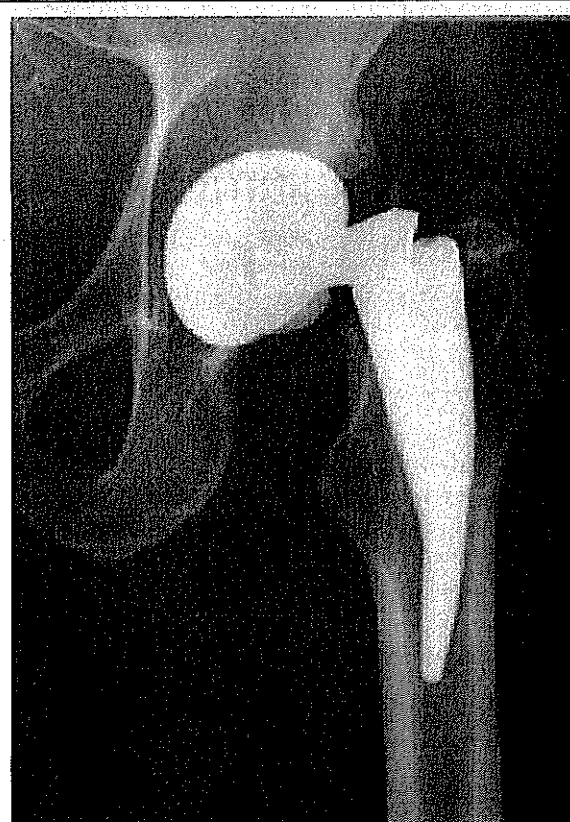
X-ray of a hip with a failed neck.
